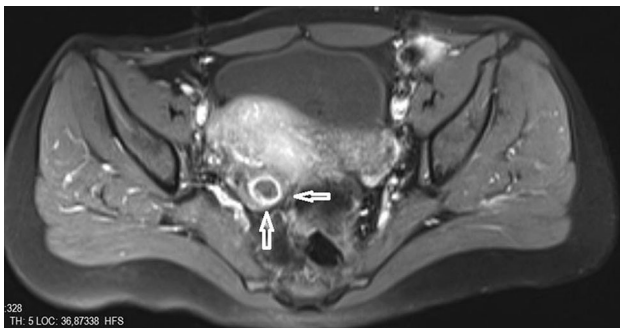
T1-weighted axial pelvic MRI with fat suppression showing (arrows) contrast enhancing right ovarian cystic teratoma
